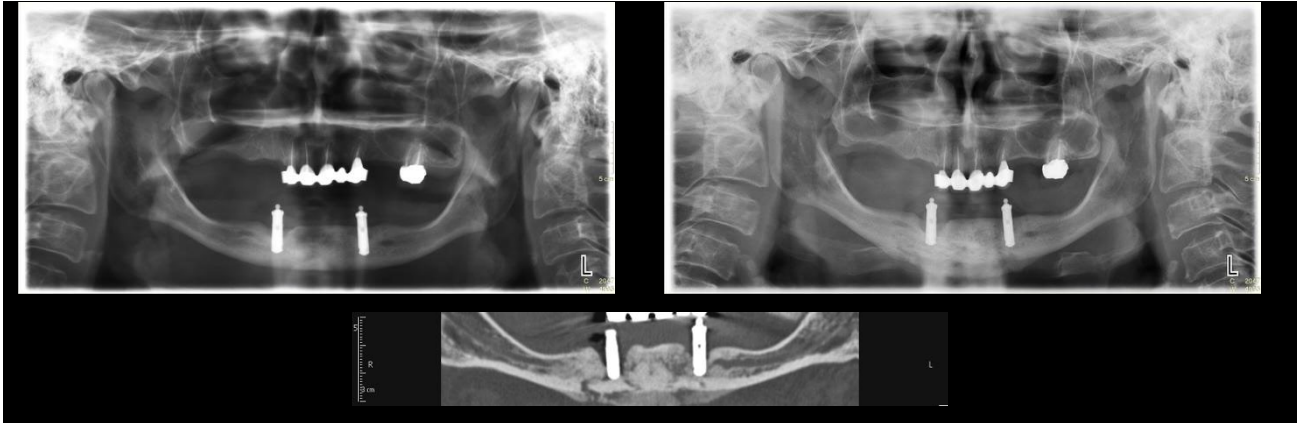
From top left clockwise: initial OPT shows no signs of MRONJ, only nonspecific signs of peri-implantitis and a very thin periosteal reaction area at the base of the mandible; OPT at the next check shows a clear picture of MRONJ; CT is the only method capable of providing important details of the lesion such as fistulous routes.
